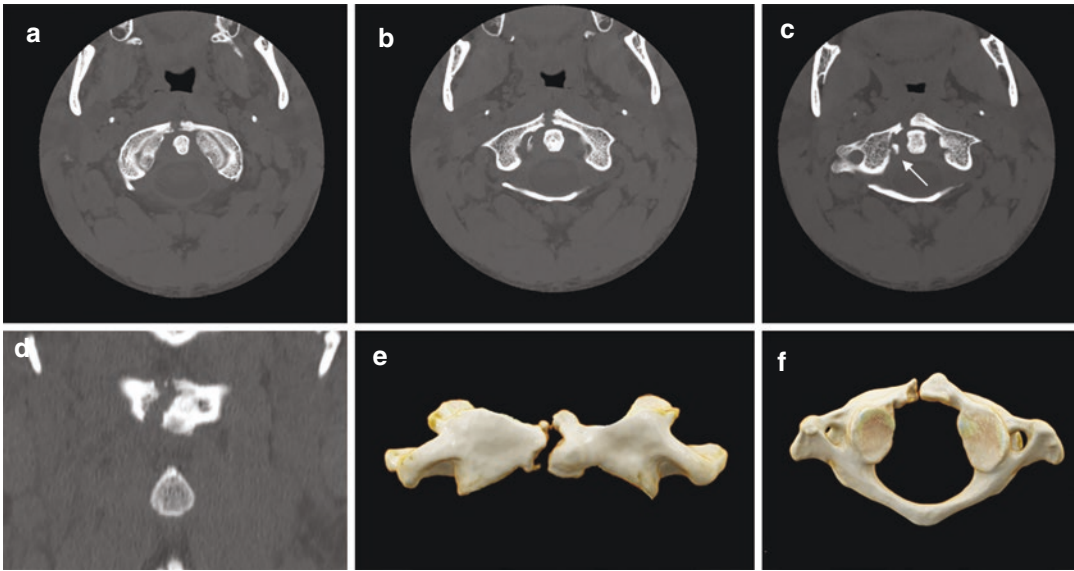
A 54-year-old man admitted to the Emergency Department with a history of car accident. Axial (a–c) and coronal (d) CT images show a fracture of the anterior arch of the atlas (type I sec. Landels, and type III sec. Levin and Edwards), and partial avulsion of the right tubercle for the insertion of the transverse ligament on the C1
